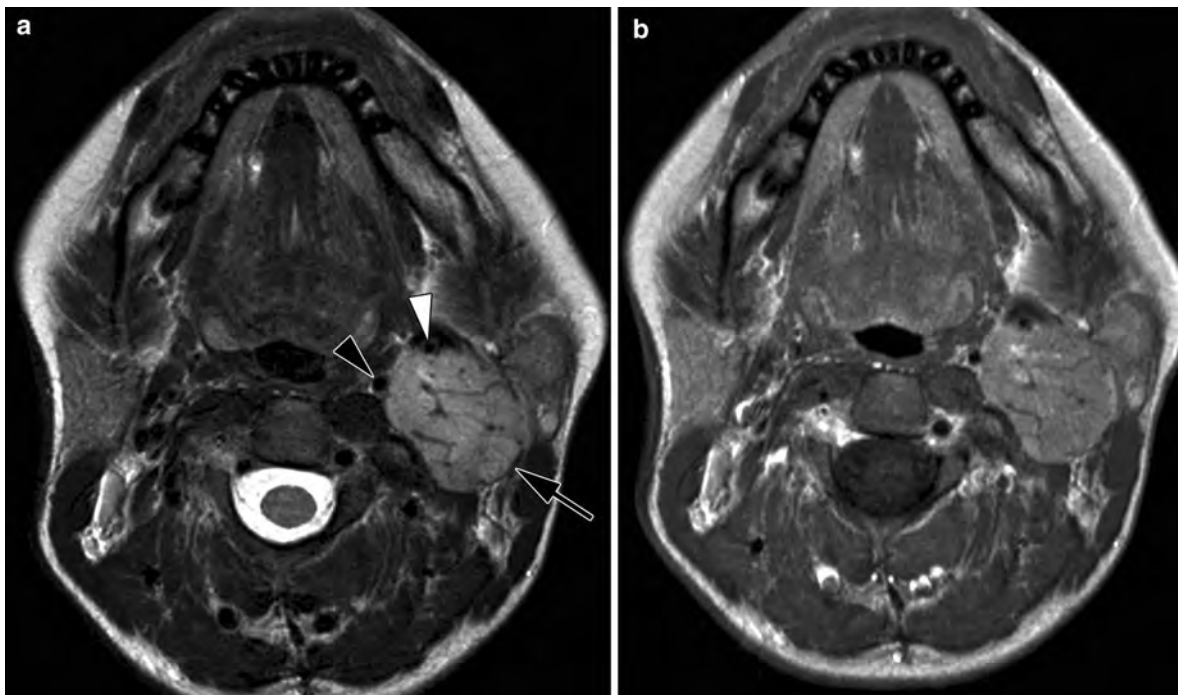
Axial T2-weighted (a) and gadolinium-enhanced T1-weighted spin echo image (b) in a patient presenting with a submandibular swelling. A mass lesion is seen in the retrostyloid compartment of the PPS, separating the internal carotid artery (*black arrowhead*) and internal jugular vein (compressed, *arrow*). The lesion also displaces the external carotid
